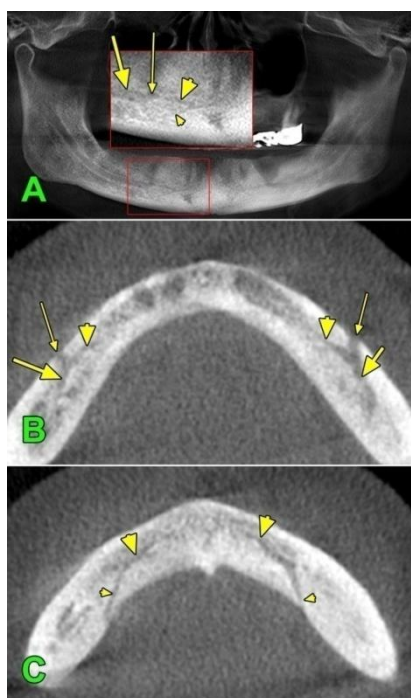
CB CT evaluation of a 59 years old edentulous female patient. The reconstructed panoramic radiograph is presented in (A); (B) and (C) present successive oblique/axial MPRs through the mandibular body. Inset in (A) presents details of the right hemimandible canals. There are indicated: the mandibular canal (thick arrow), the mental foramen (thin arrow), the incisive canal (thick arrowhead) and bilateral canals (thin arrowheads) leaving the incisive canals and downturning to open through the lingual cortical plates of the mandible
